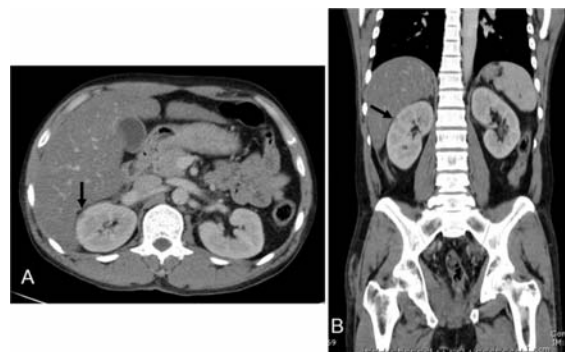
Grade 2 renal injury. A 40-year-old male presented with pedestrian injury. CT shows small renal laceration (arrow) at the interpolar region of right kidney, measuring about 0.7 cm in depth.
